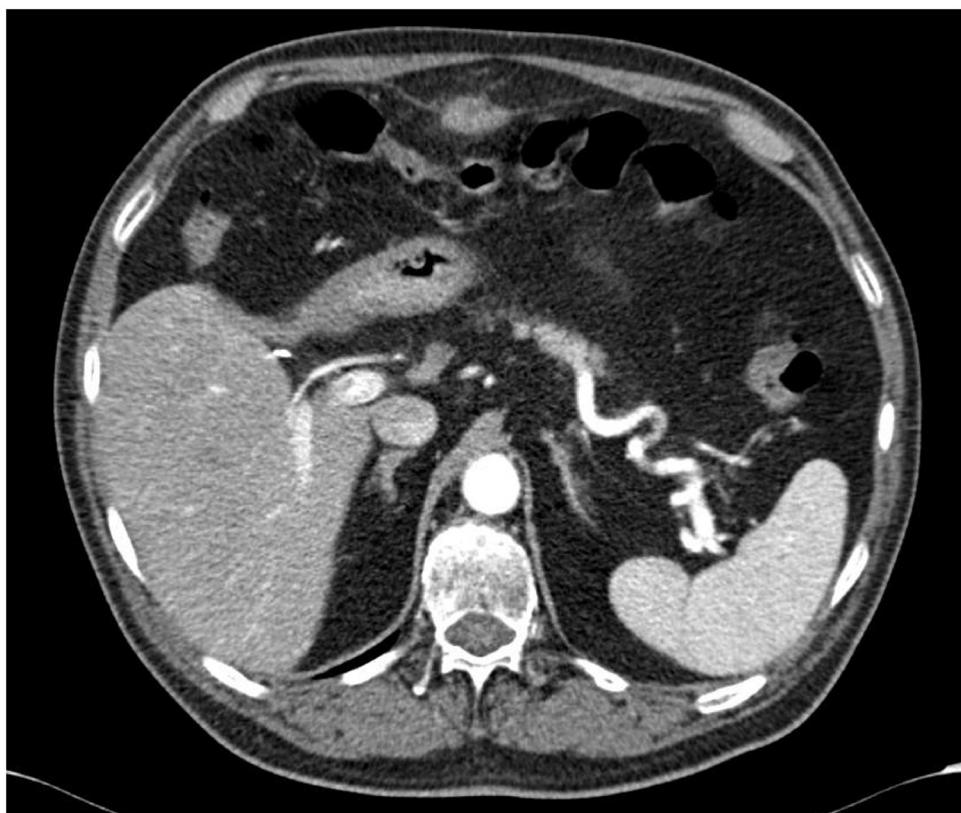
CT scans of the abdomen and pelvis, demonstrating multiple hyperdense soft tissue nodules mimicking peritoneal carcinomatosis.
